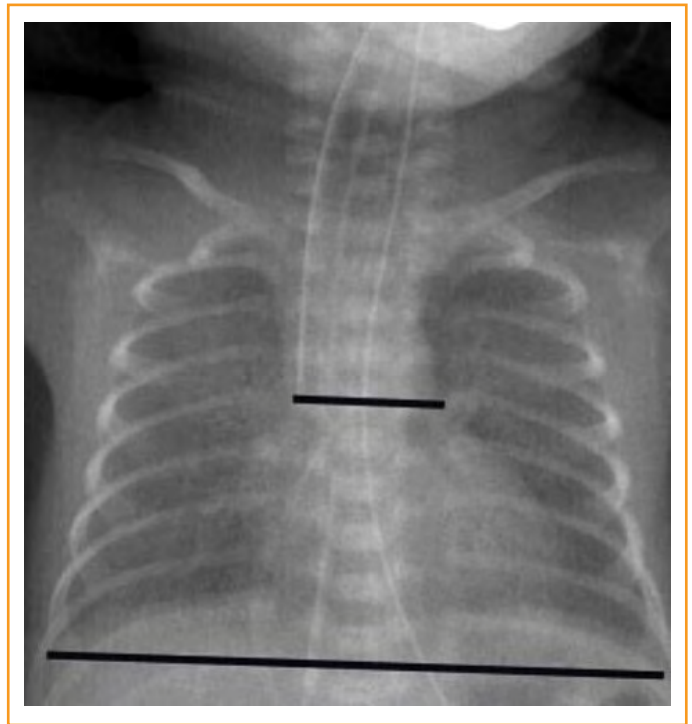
CT/T in VLBW preterm infants is measured on portable anteroposterior chest radiographs by dividing the width of the cardiothymic image at the level of the carina by the transverse diameter of the thorax at the level of the costophrenic angles.
